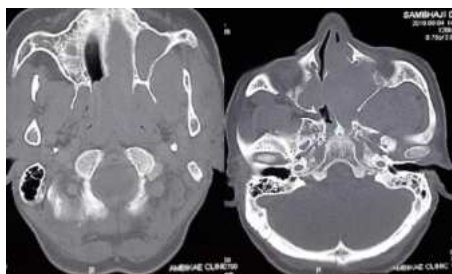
CT PNS with Brain in axial view
